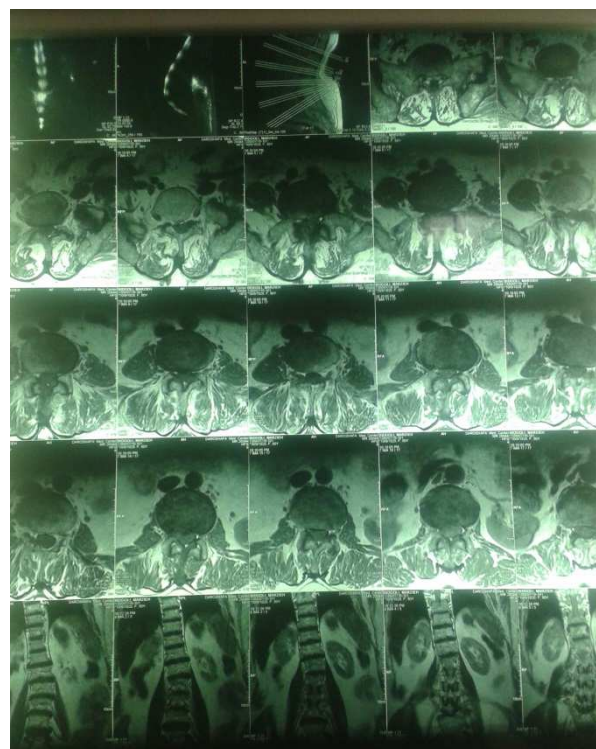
Lumbosacral MRI of patient
